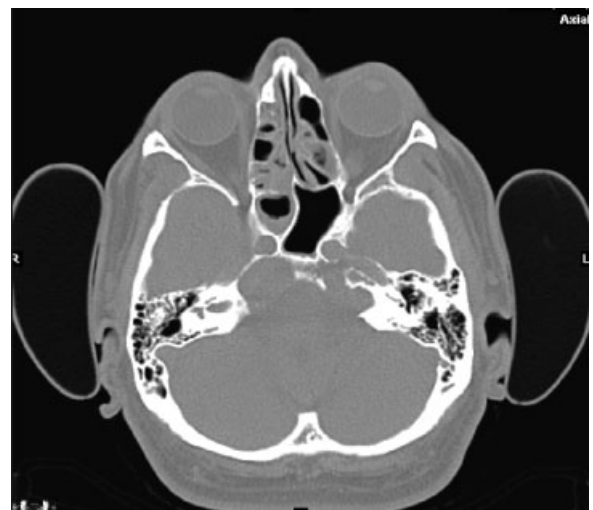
CT scan demonstrating bilateral cholesterol granuloma of petrous apices and chronic rhinosinusitis (case 1).
